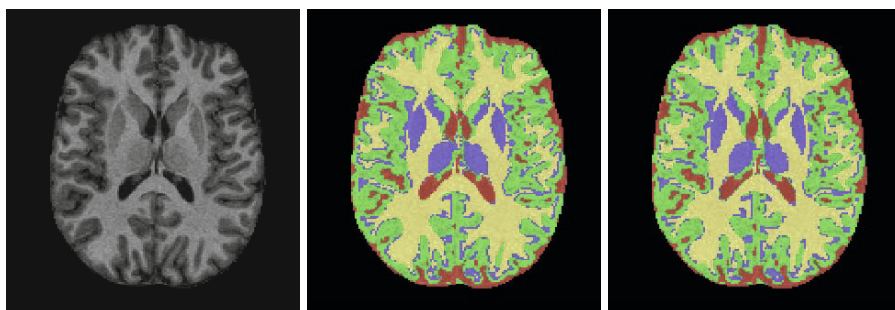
Comparison of MAP estimates found by Laplace relaxation (middle) and the VEM algorithm (right) for a skull-stripped MR T1-weighted image (left). Label colors are red for CSF, blue and green for GM, and yellow for WM.
